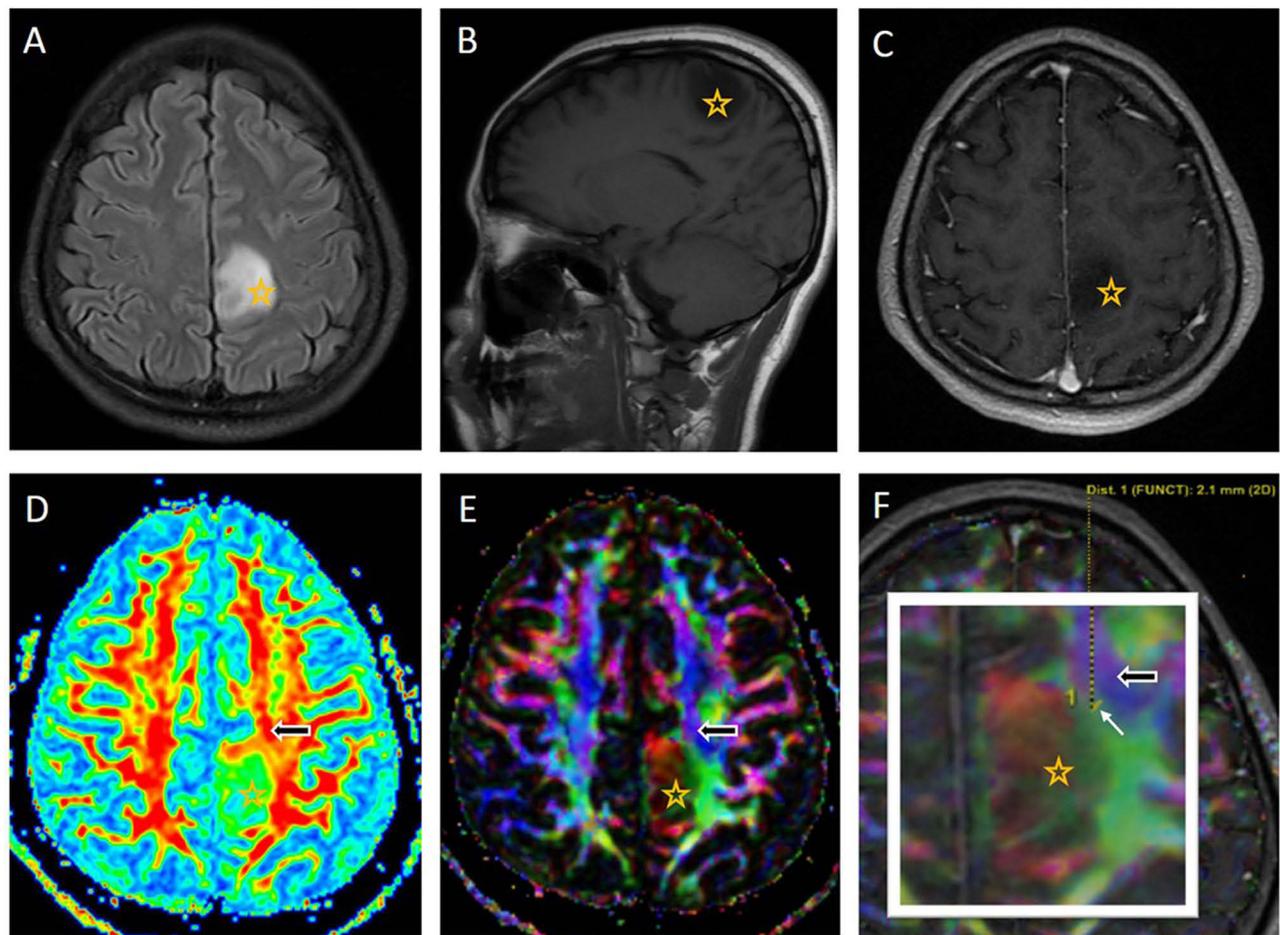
Diffusion tensor imaging of the brain of a 34-year-old woman with a left frontal–parietal diffuse astrocytoma (grade II). Axial fluid-attenuated inversion recovery (A), pre-contrast T1-weighted (T1W) (B), and post-contrast T1W (C) images show a homogenous tumor (indicated by a star in (A–F)), with no enhancement and no peritumoral edema. The tumor appears to slightly and laterally compress the left corticospinal tract (CST) (indicated by black arrow in (D–F)). The combination of the color-coded map and post-contrast T1W (F) shows a glioma-to-CST distance of 2.1 mm (indicated by white arrow).
